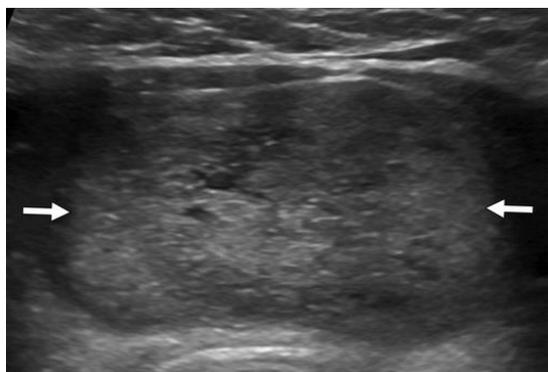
Transverse ultrasound image shows 3 x 2 cm solid nodule at thyroid isthmus.
